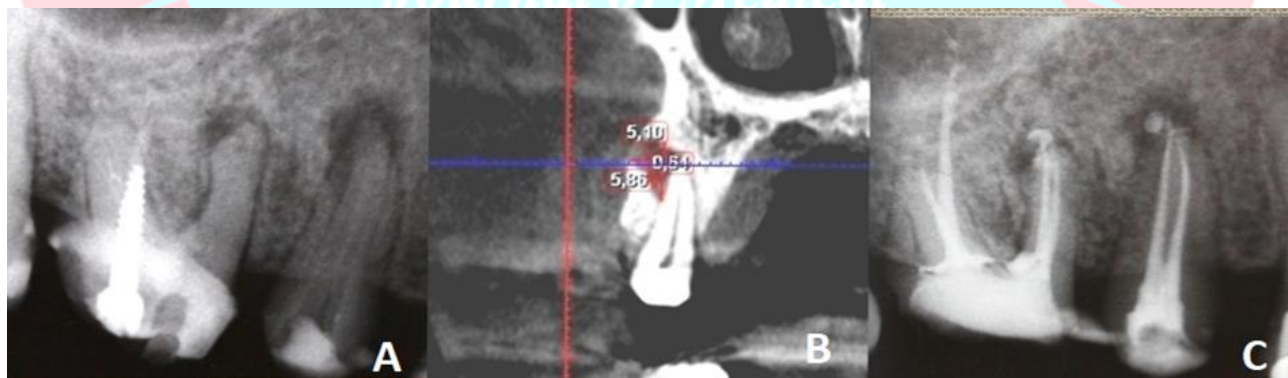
(A) diagnostic X-ray; (B) CBCT examination of tooth 15 with lesion' sizes 5.10 by 5.8 mm; (C); X-ray after filling the root canals.
